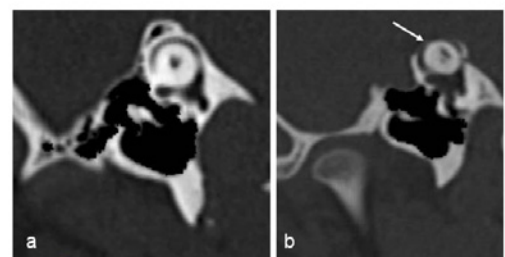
Sagittal oblique CT scans of the temporal bones show normal bone roof on the right side (a), and dehiscence (arrow) of the superior semicircular canal on the left side (b).
